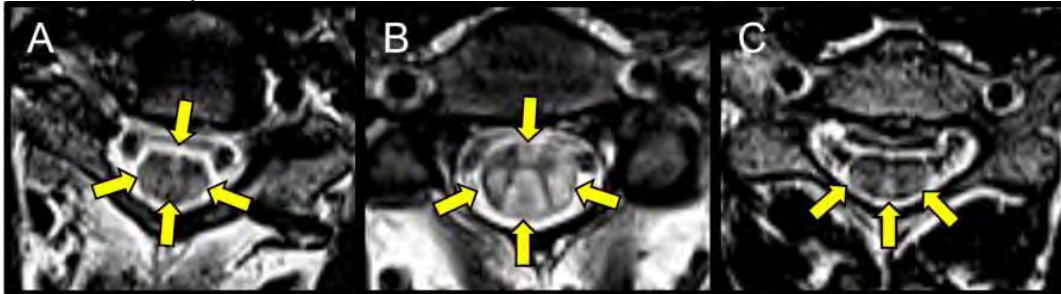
T2 weighted cervical spine MRI findings for patient 1 (A), patient 2 (B), and patient 3 (C) demonstrates hyperintense T2 signal of the cervical spinal cord involving the corticospinal tracts and dorsal columns. (yellow arrows).
